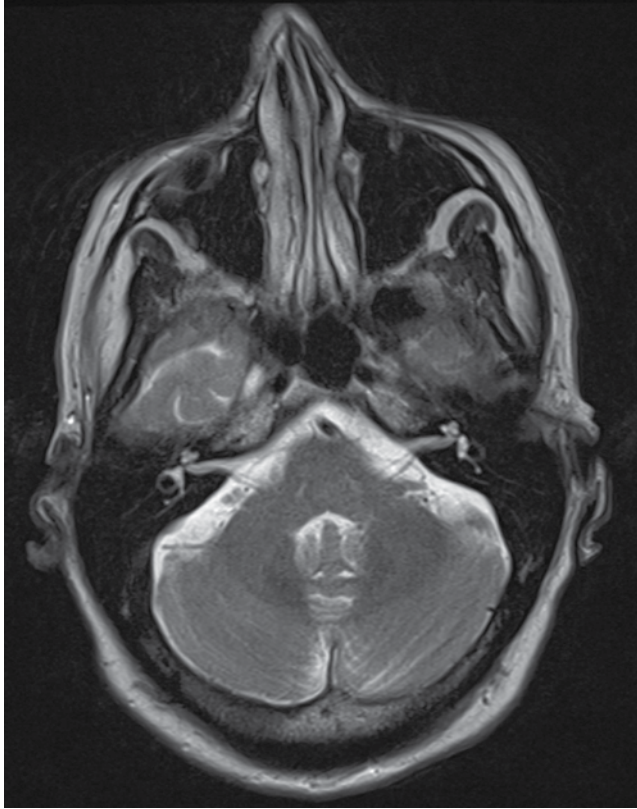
MRI brain scan with high signal consistent with central pontine myelinolysis.
